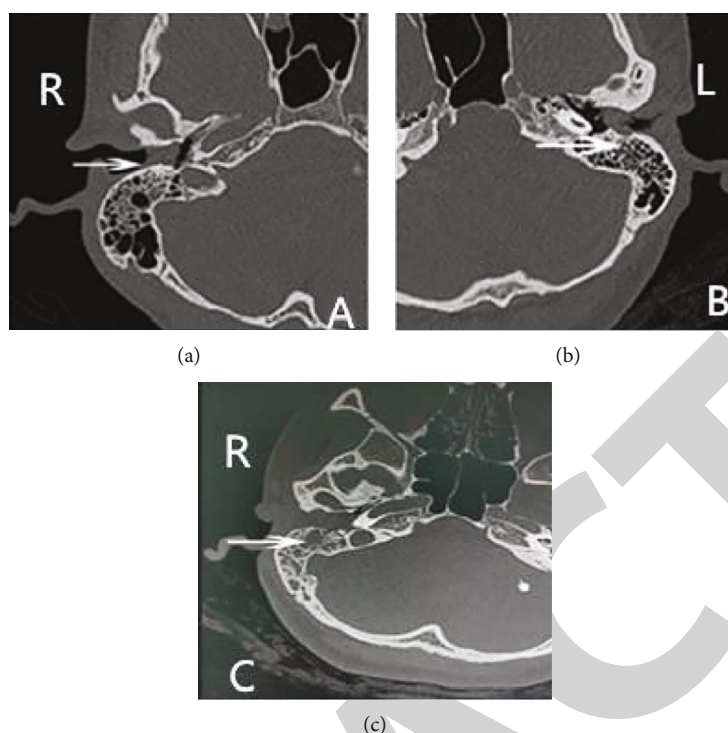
CT images of the Shin stages of EACC. Note: (a) stage I: soft tissue shadow in the right external auditory canal, the lesion is confined to the external auditory canal without bone destruction; (b) stage II: soft tissue shadow in the left external auditory canal invades the tympanic membrane into the middle ear cavity and destroys the bone of the external auditory canal wall; (c) stage III: soft tissue shadow in the right external auditory canal, not only destroys the bone of the external auditory canal but further invades the small bone of the middle ear cavity and involves the mastoid.
